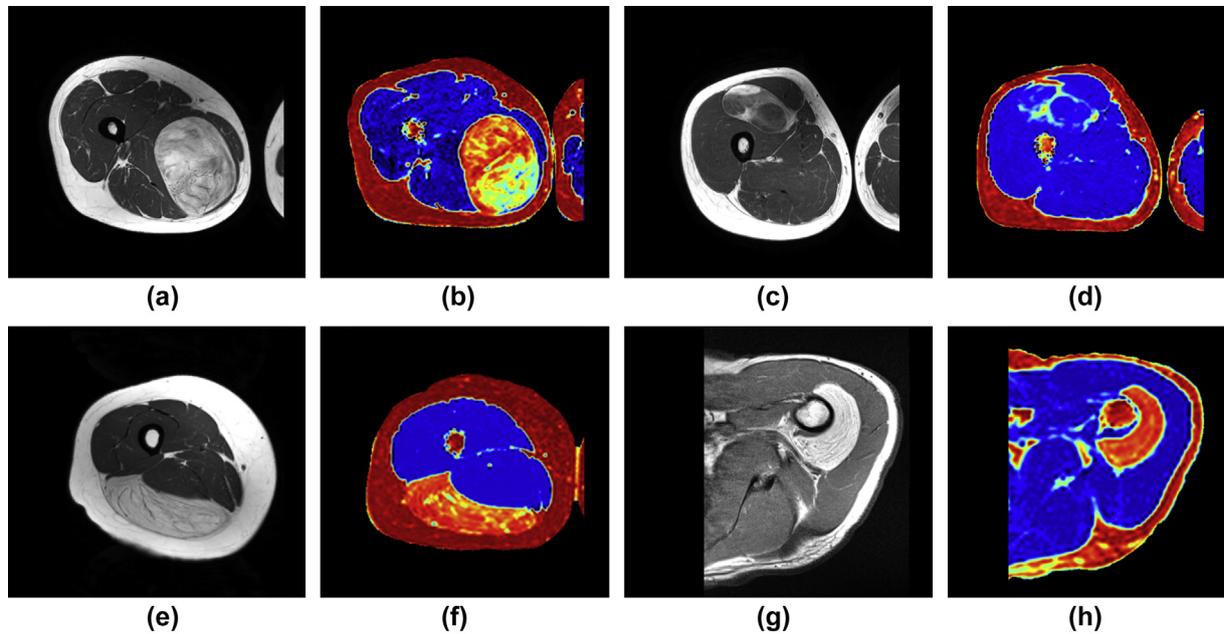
(a) T1-weighted image and (b) PDFF map (mean PDFF: 62%) of an atypical lipomatous tumour. (c) T1-weighted image and (d) PDFF map (mean PDFF: 21%) of a myxoid liposarcoma. (e) T1-weighted image and (f) PDFF map (mean PDFF: 76%) of a lipoma. (g) T1-weighted image and (h) PDFF map (mean PDFF: 82%) of an atypical lipomatous tumour.
